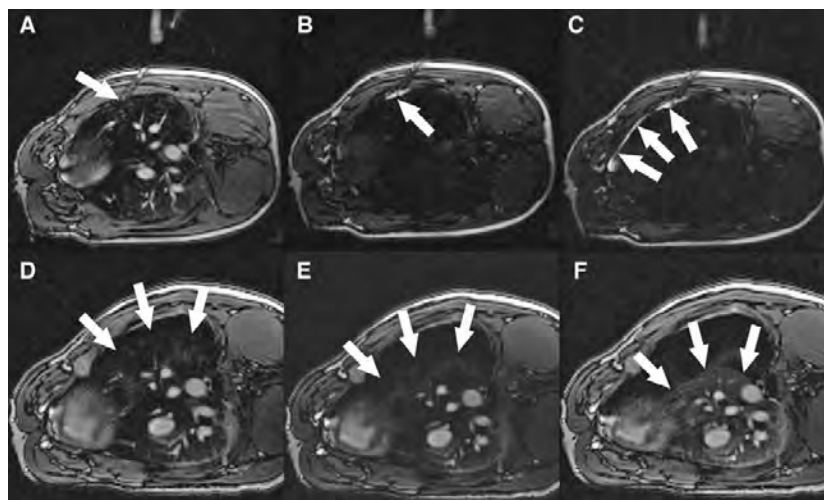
Magnetic resonance imaging (MRI)-guided pleural insufflation to displace lung. A, Needle (arrow) is advanced through the chest wall toward the pleura. B, Saturation mode MRI darkens tissue to enhance visibility of gadolinium contrast. Small aliquots of contrast injected through the needle (arrow) show that the tip is still within the chest wall. C, After advancing the needle further, contrast flows freely around the lung in the pleural space (arrows). Saturation mode MRI is then toggled off. D–F, After insertion of a drain, the pleural space is insufflated with CO₂ to deflate the lung despite positive pressure ventilation. Arrows indicate lung margin during progressive pleural insufflation.
